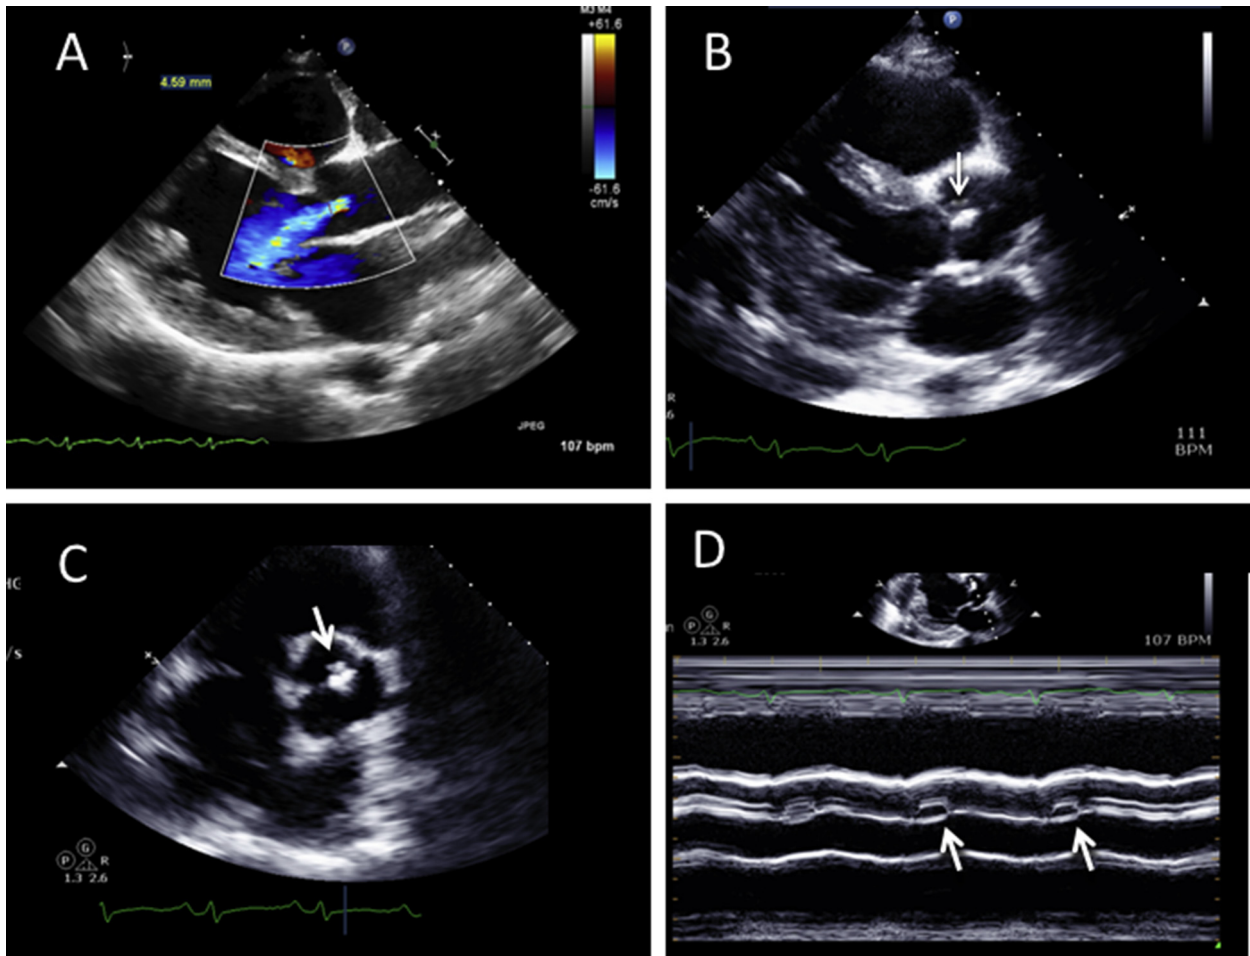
(A) TTE color Doppler shows moderate central AR before LVAD implantation. Intraoperative assessment revealed subtle cusp prolapse with good tissue integrity, so a central coaptation (*Park*) stitch was placed. See also [Video 1](#). (B) TTE 2D imaging of the AV shows the central coaptation stitch in the parasternal long axis (B) and short axis (C) (arrows). See also [Videos 2](#) and [3](#). M-mode imaging (D) shows residual cusp separation near the cusp commissures during reduced LVAD pump speed, but no residual AR was present.
